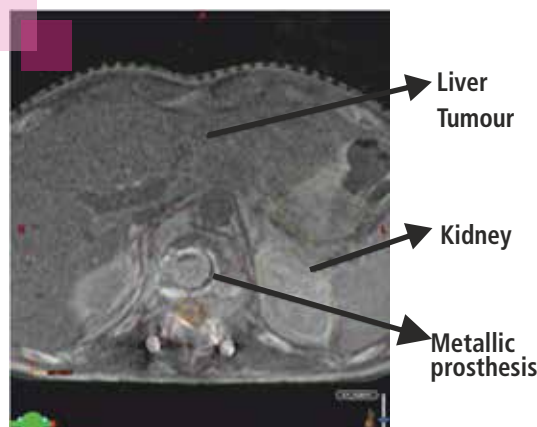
Stereotactic radiation (SBRT) delivered under MRI guidance
